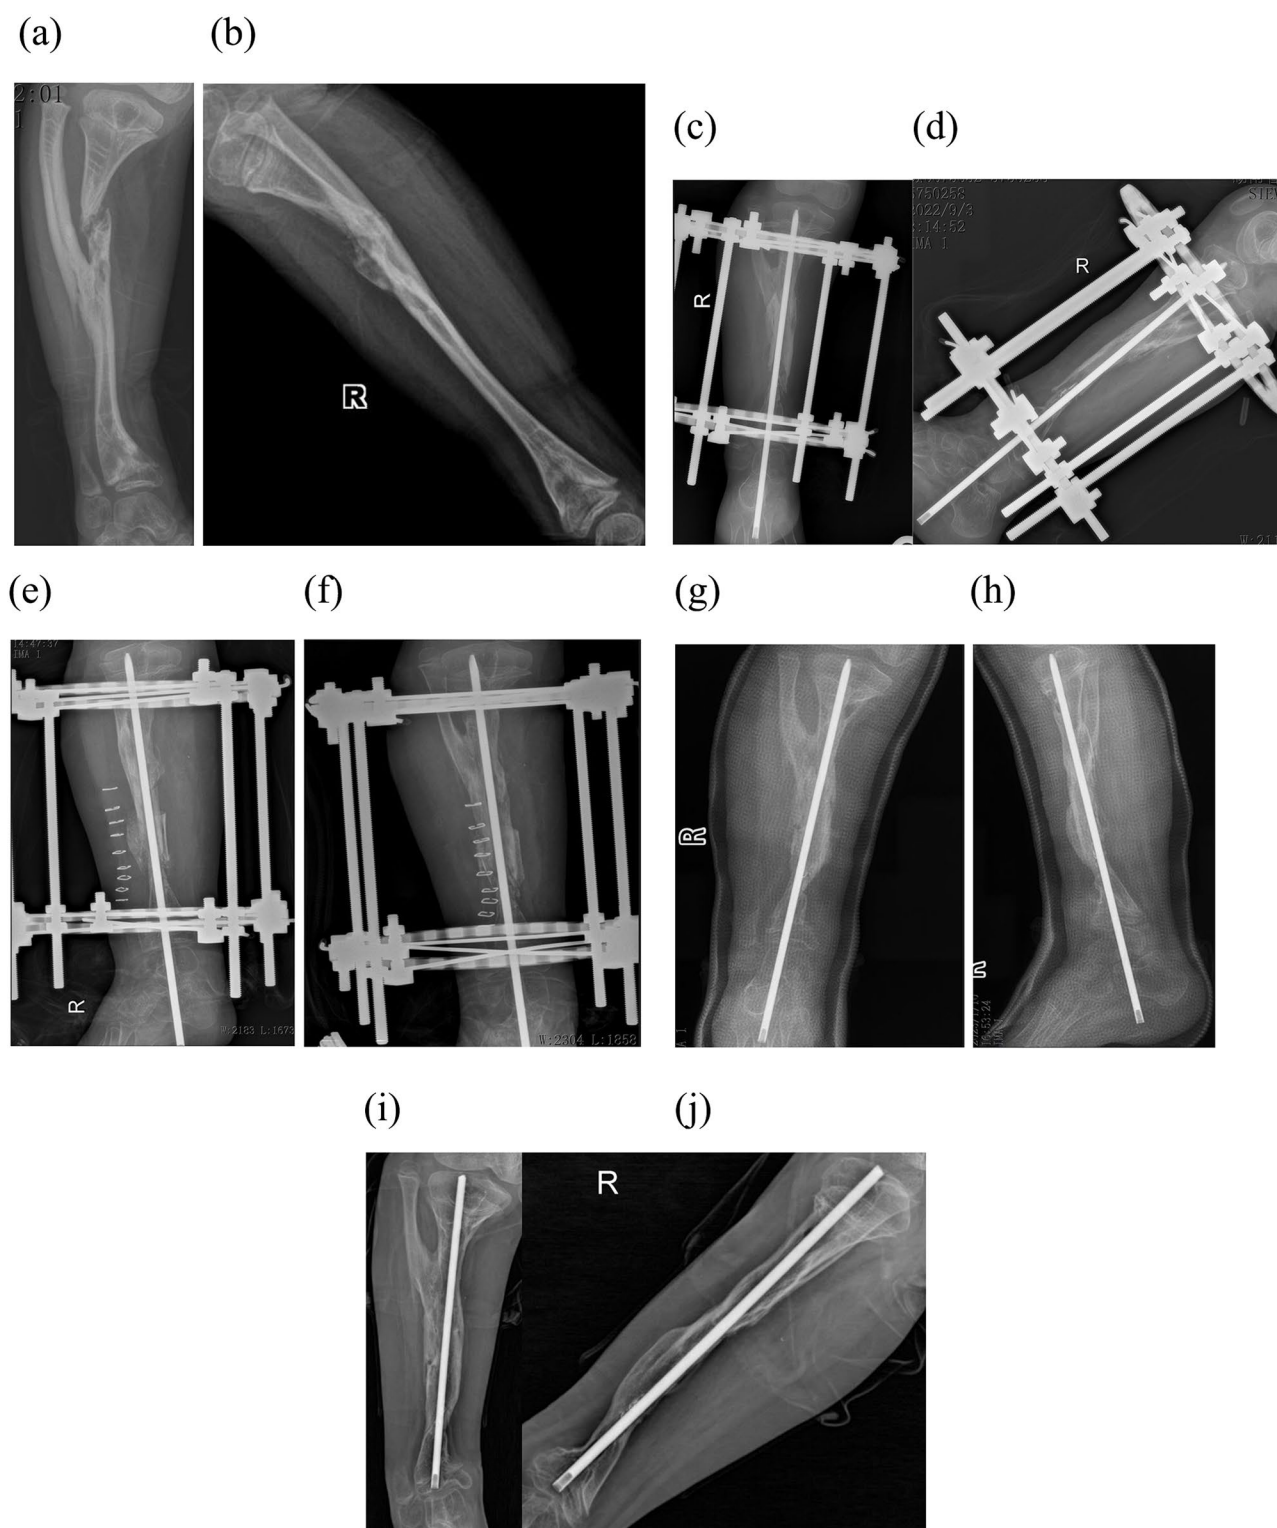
(a, b) CPT, female, 5 years old, preoperative anteroposterior and lateral X-ray. (c, d): 11 months postoperative anterior and lateral X-rays of the tibia and fibula shows that tibial osteotomy did not achieve union in the distal of tibia. (e, f): A wrapped autogenous iliac bone graft was applied for this patient. (g, h): Union was achieved after a wrapped autogenous iliac bone graft was applied for four months. (i, j): Postoperative anterior and lateral X-rays of the tibia and fibula after a wrapped autogenous iliac bone graft for 15 months
